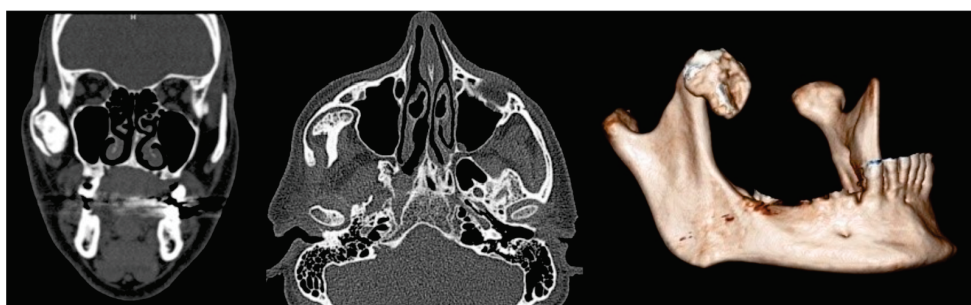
Coronal (left), axial (center), and 3D reconstructed (right) CT images demonstrating an enlarged and elongated right coronoid process.
